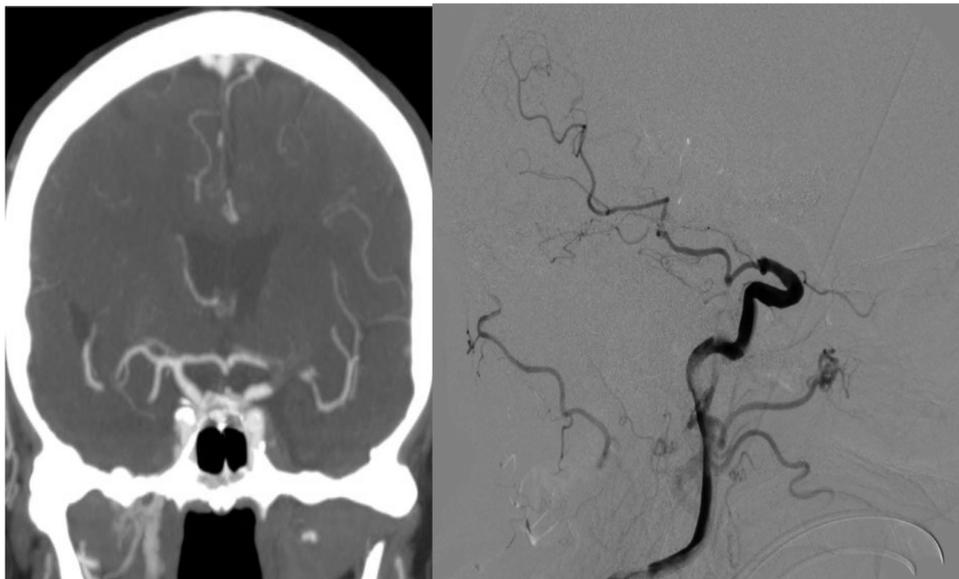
Patient with acute terminal ICA occlusion, with contrast meeting with the proximal face of the clot in the arterial phase of the CTA. DSA shows a distal ICA occlusion, with patency of the posterior communicating, anterior choroidea, and ophthalmic arteries.
